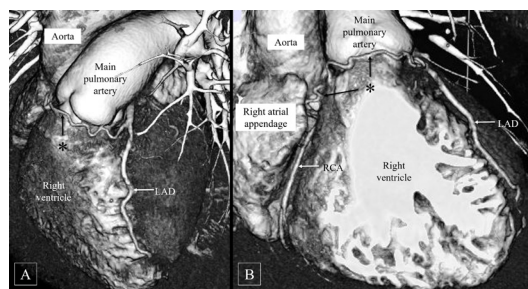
Volume-rendered CT angiography images (A and B) depict the course of the tortuous collateral, traversing anterior to the right ventricular outflow tract and reaching the right atrioventricular groove.
